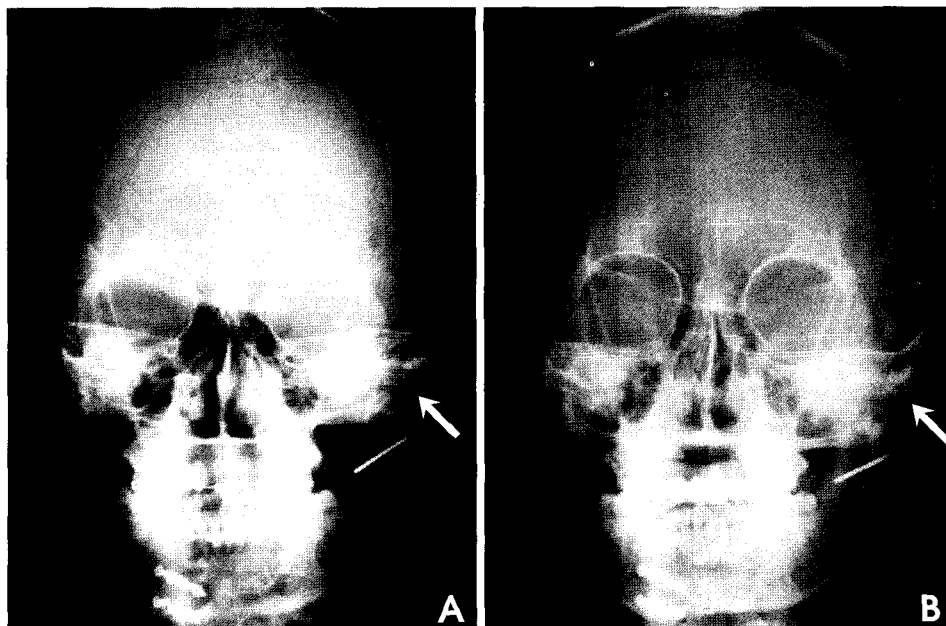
Cephalometric posteroanterior skull radiographs show the mandibular asymmetry of the operative treatment patient. A, immediately after operation (AI: 8.9) B, 5 years after operation (AI: 3.9)
